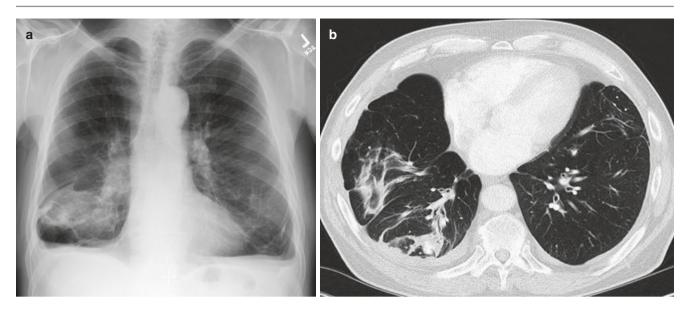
Comet tail sign in round atelectasis. (a, b) Frontal radiograph and axial CT image show all criteria for rounded atelectasis (subpleural opacity, comet tail sign, volume loss, and pleural effusion)
